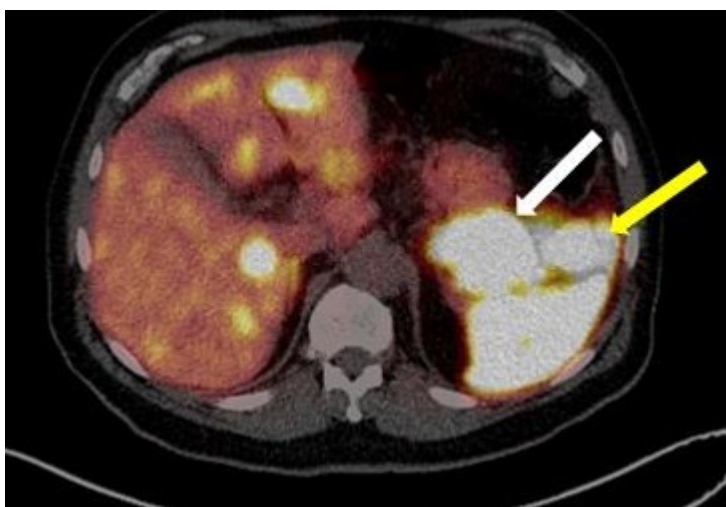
Detection of pancreatic primary and metastases with ^{68}Ga -DOTA-NOC PET/CT
